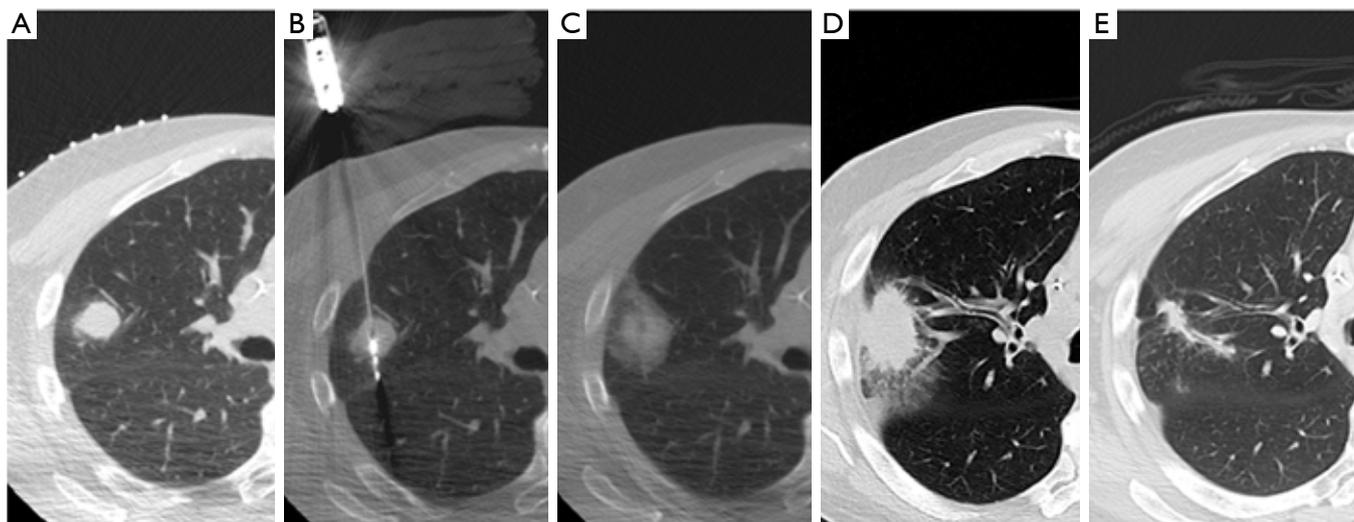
(A) Axial CT image shows a 2.2 cm right upper lobe lesion; (B) Image during microwave ablation shows a single microwave probe positioned within the tumor; (C) Immediate post-ablation image shows groundglass opacity surrounding the lesion, which is penetrated by probe tracts; (D) Follow-up CT image 3 months after microwave ablation shows a larger consolidation consistent with expected post-ablation change; (E) CT at 9-month follow-up shows near resolution of consolidation with residual parenchymal scar
